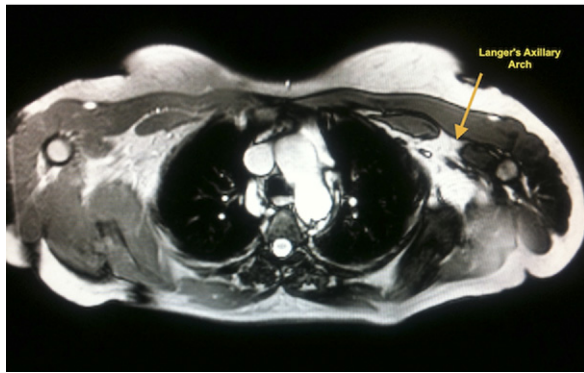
Magnetic resonance image demonstrates the Langer's axillary arch (LAA).
